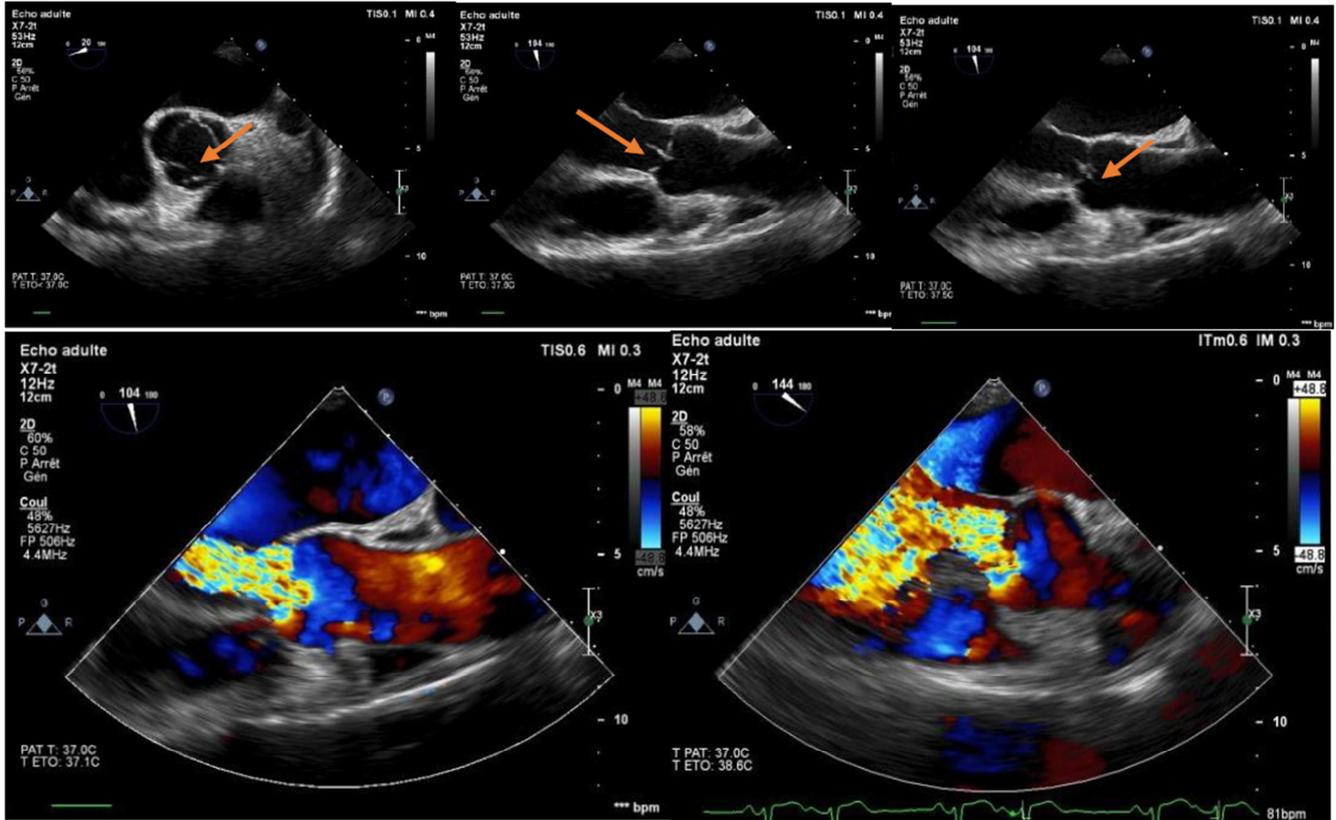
Transoesophageal echocardiographic images showing partial rupture of the antero-right sigmoid with massive aortic insufficiency.
